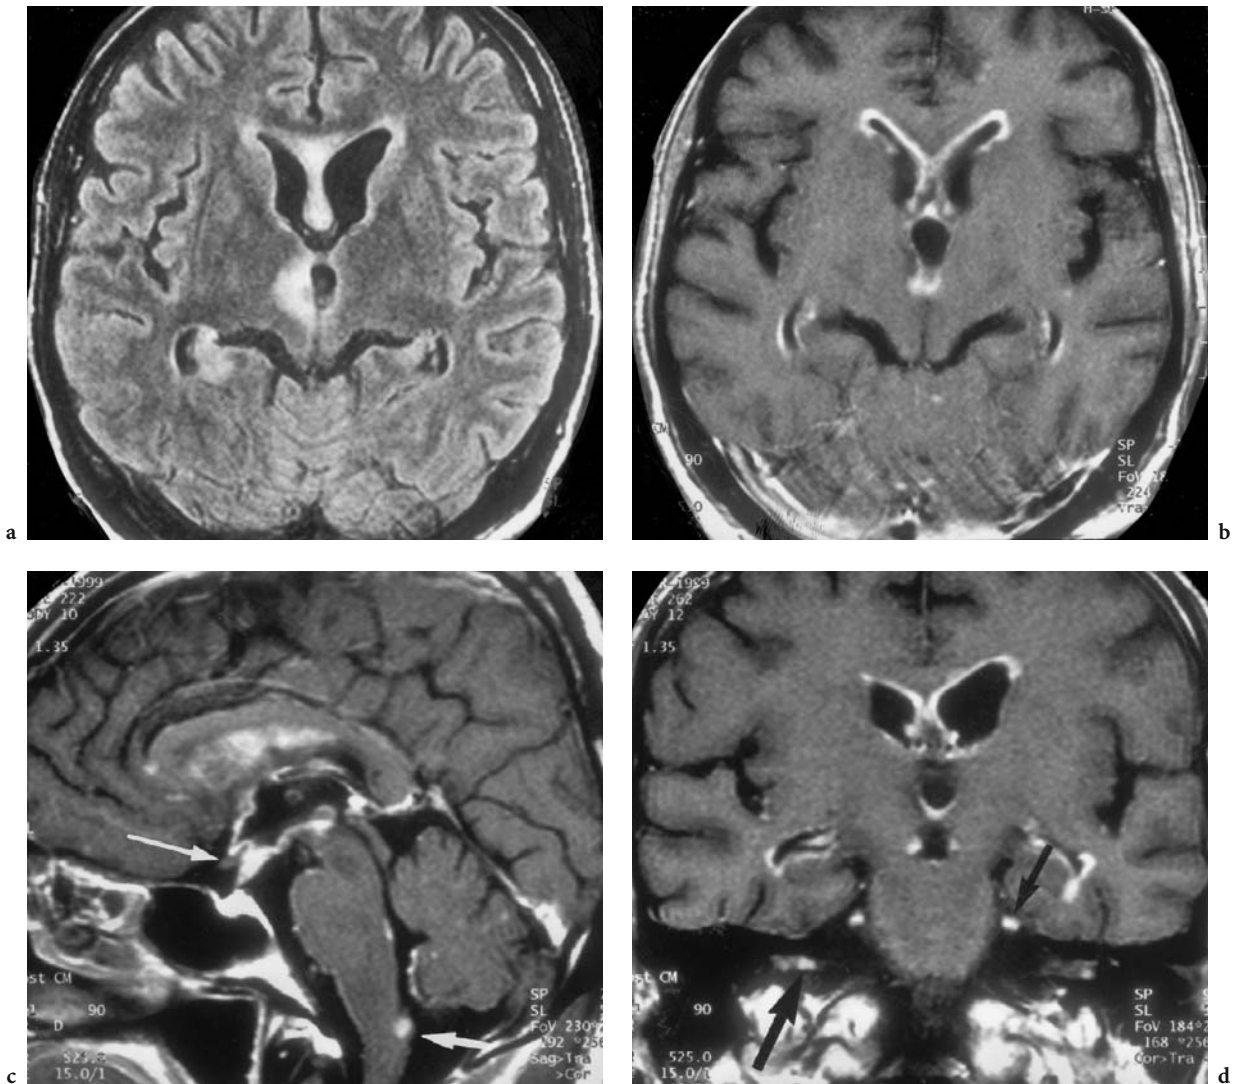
A 68-year-old man with known NHL VI a, suffering from an acute bilateral visual deficit associated with anacusis. Diagnosis: leptomeningeal NHL metastasis. MRI: a Axial T2-weighted FLAIR view with periventricular signal enhancement in the right thalamus and corpus callosum, indicating perifocal edema. b Corresponding T1-weighted, contrast-enhanced view with ependymal signal enhancement of the tumorous infiltration. c Midsagittal, T1-weighted, contrast-enhanced view with superior visualization of the cast of the infundibular and chiasmal recess of the third ventricle. Note signal enhancement of the ventricle ependyma, of the third and lateral ventricle, as well as meningeal metastasis at the obex (entrance of the central canal, *short white arrow*) but identification of the chiasm itself (*long white arrow*). d Coronal, T1-weighted, contrast-enhanced image demonstrating additional involvement of both trigeminal nerves in their cisternal course (*small arrow* indicating the left) and both vestibular nerves inside the internal auditory canal (*large arrow* on the right)
